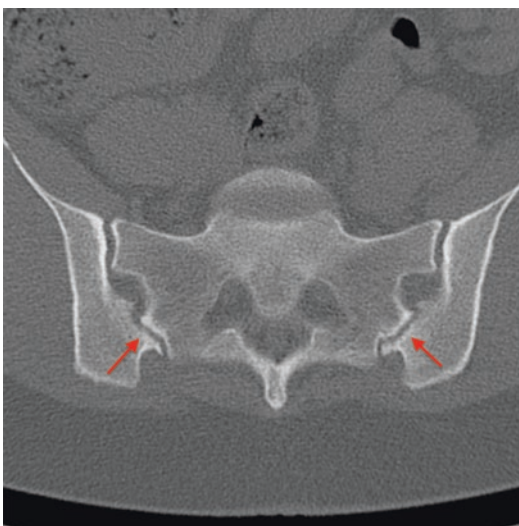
Axial CT image shows bilateral accessory SIJ (red arrows), a common normal variant, which occasionally may become symptomatic
